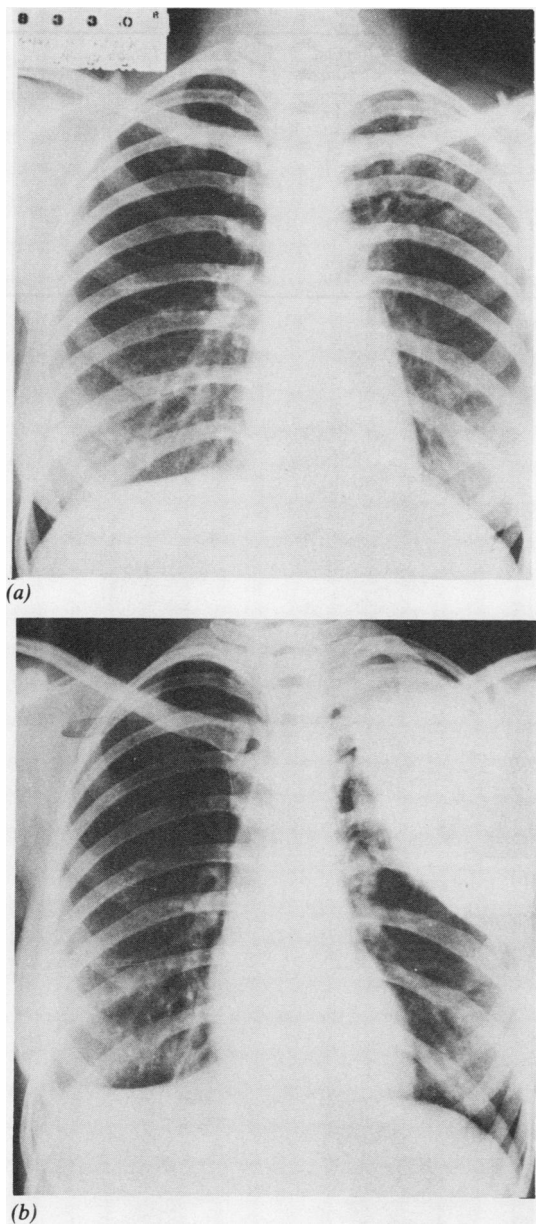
(a) Chest radiograph showing a typical tuberculous cavity for treatment by plombage. (b) Postoperative chest radiograph of the same patient four years after left polystyrene sponge plombage.
